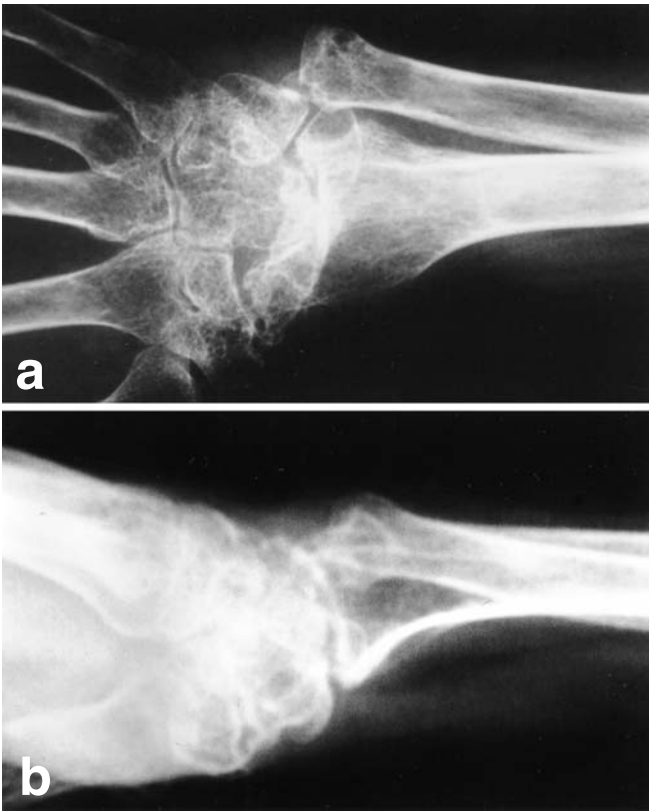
Preoperative radiographs. a Anteroposterior view. b Lateral view
